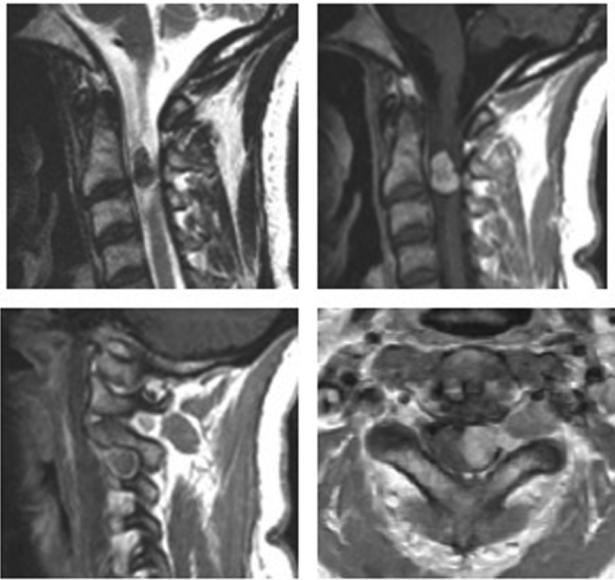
Preoperative magnetic resonance imaging (MRI) of the cervical spine with and without contrast demonstrated a T1-hyperintense, T2-hypointense, homogeneously enhancing, dumbbell-shaped, intradural extramedullary mass extending out through the left C2–C3 foramen.
